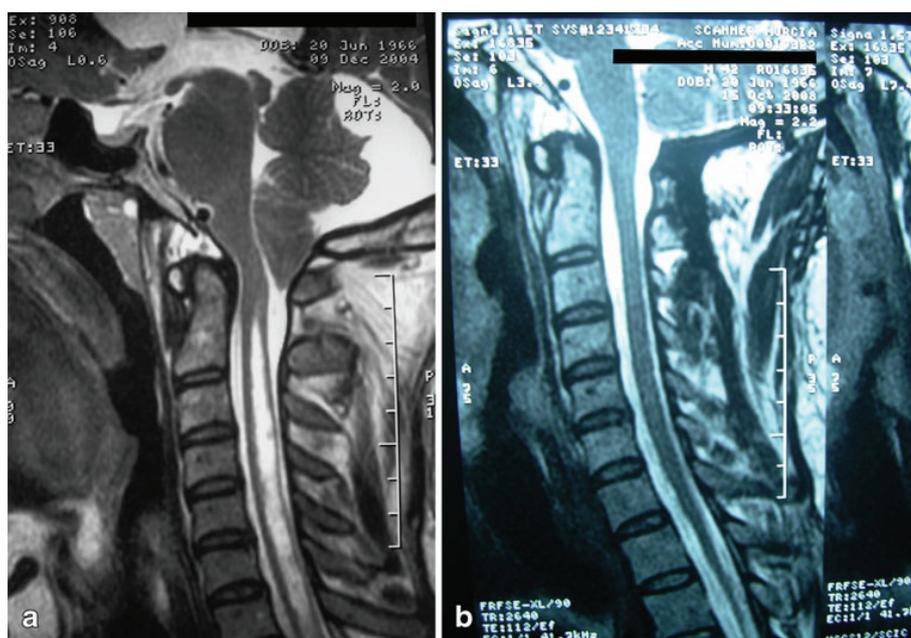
Patient 2. MRI T1 sagittal shows in a patient with achondroplasia, hydrocephalus, and platybasia, a midline posterior fossa arachnoid cyst and associated Chiari I malformation. This patient had resolution of hydrocephalus, cervical syrinx, and Chiari symptoms after insertion of a VP shunt
